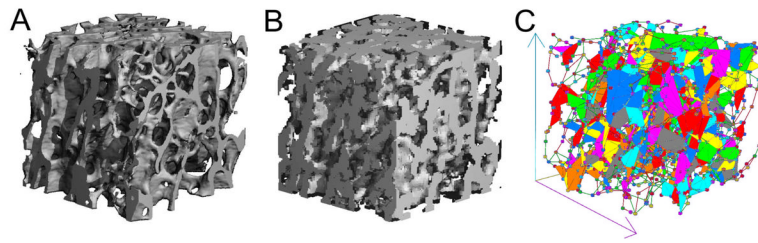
The 3D reconstruction of a registered (A) μ CT and (B) HR-pQCT cubic trabecular bone images of human tibia. Based on (B), a PR model was generated and shown in (C). Color indicates different individual trabecula.
